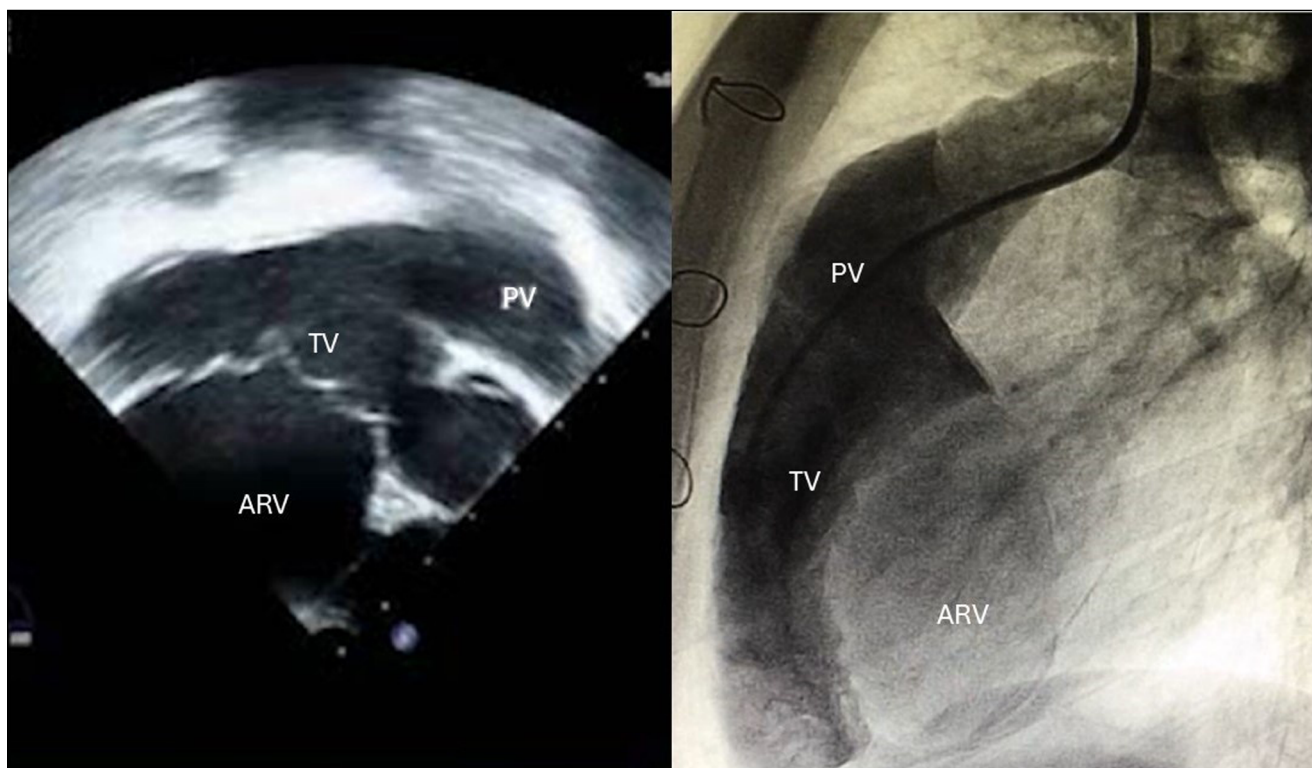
(A) Echocardiogram and (B) heart catheterization images of a cyanotic patient, showing a rotated tricuspid valve into the right ventricular (RV) outflow tract, with a small functional RV. PV: pulmonary valve; TV: tricuspid valve; ARV: atrialized right ventricle
